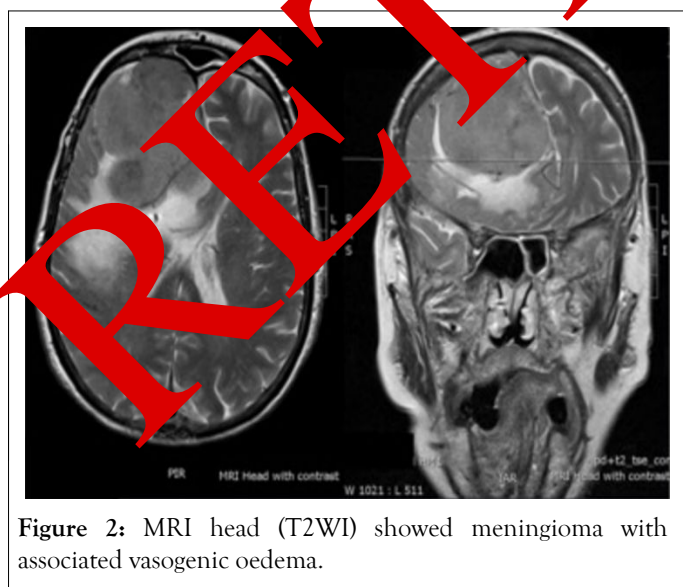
MRI head (T2WI) showed meningioma with associated vasogenic oedema.
